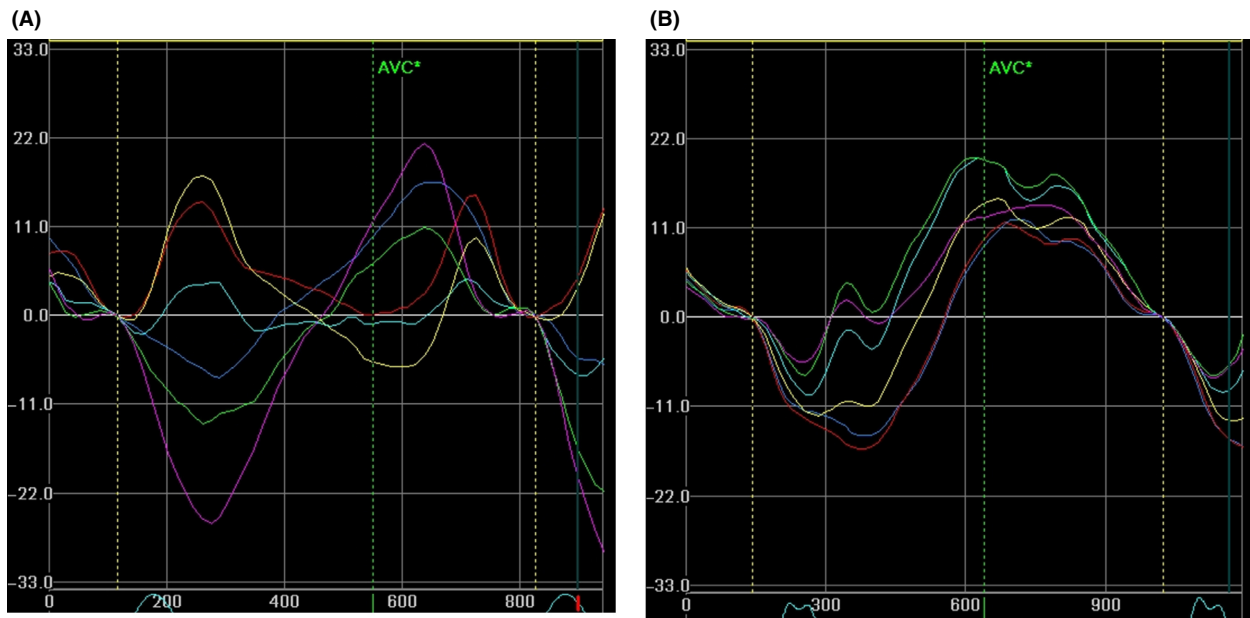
Velocity Graphs assessed by tissue Doppler images with low output of the LV pacing (A) and with high output of the LV pacing (B) during CRT. Improvement of the mechanical dyssynchrony with the high output at 3.5V was shown compared with the low output at 2.5V.
